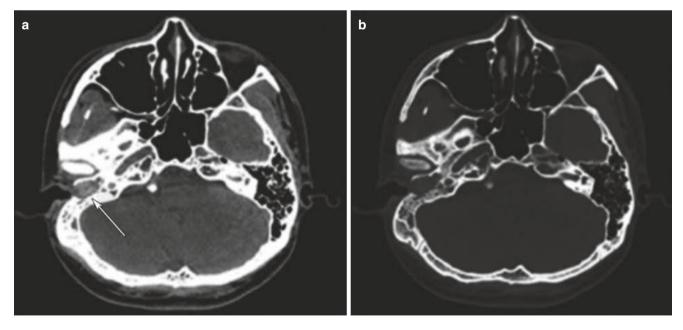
Temporal axial CT scan of right chronic middle ear mastoid otitis. (a) Soft tissue window CT plain scan; (b) bone window CT plain scan. Well-gasified left mastoid, no abnormality; small right mastoid
